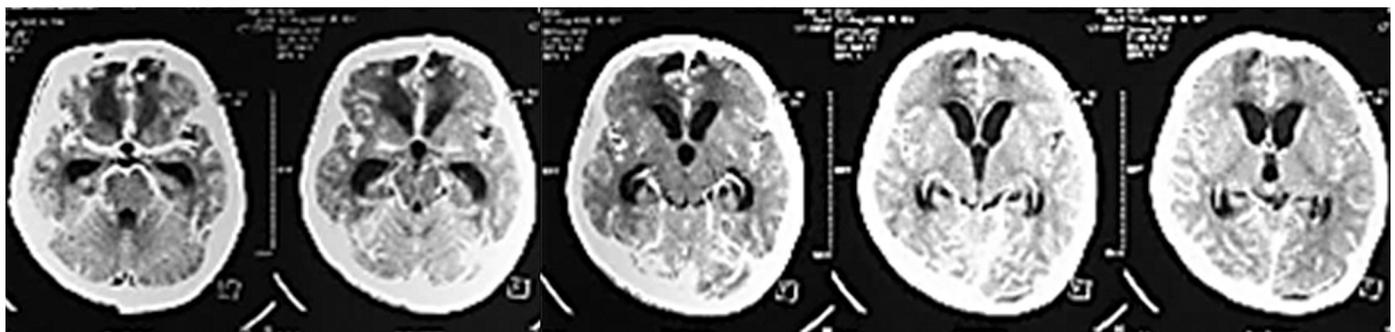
Contrast CT images showed meningeal enhancement and isohypodense mass with enhancement at a mid-frontobasal.
